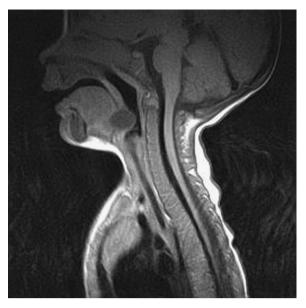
T1-weighted MNR showing a hypointense rounded lesion overwhelming the epiglottis.
